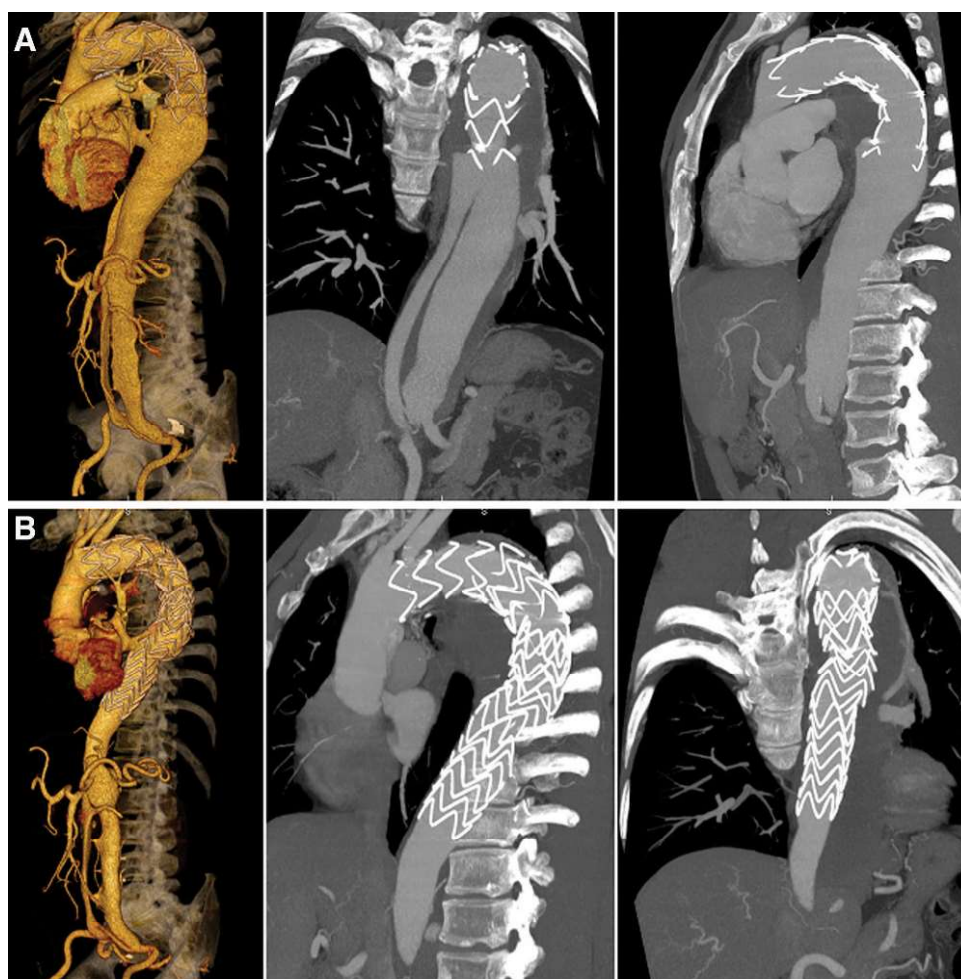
♦ CTA with 3D volume rendering and multiplanar reconstructions of a man undergoing TEVAR for acute aortic dissection in a referring hospital: (A) upper series demonstrates a second entry distal to the stent-graft causing persisting false channel perfusion and rapid expansion. (B) Lower images show successful reintervention with a second stent-graft.
